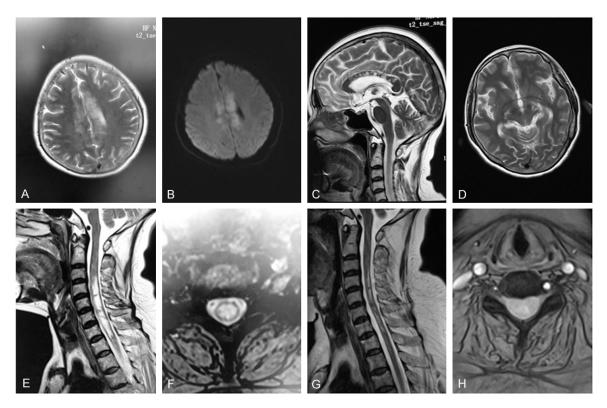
Brain and spinal cord MRI of the patient showing the infarction in corpus callosum and left centrum ovale (A-C), deformation changes in cerebral peduncle (D), and syringomyelia cavitations from C3 to T1 vertebral segments (E, F). After effective steroid therapies, the spinal cord MRI demonstrating the resolution of inflammatory lesions and syringomyelia cavitations (G, H).
